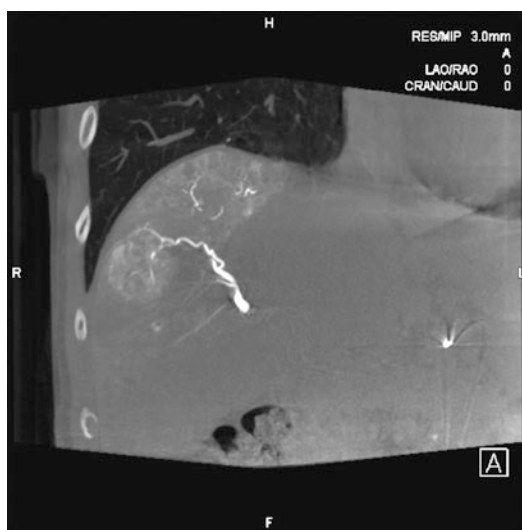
99m Tc-MAA injection site in right hepatic artery. An intraprocedural Cone Beam CT did not show any aberrant vascularization
